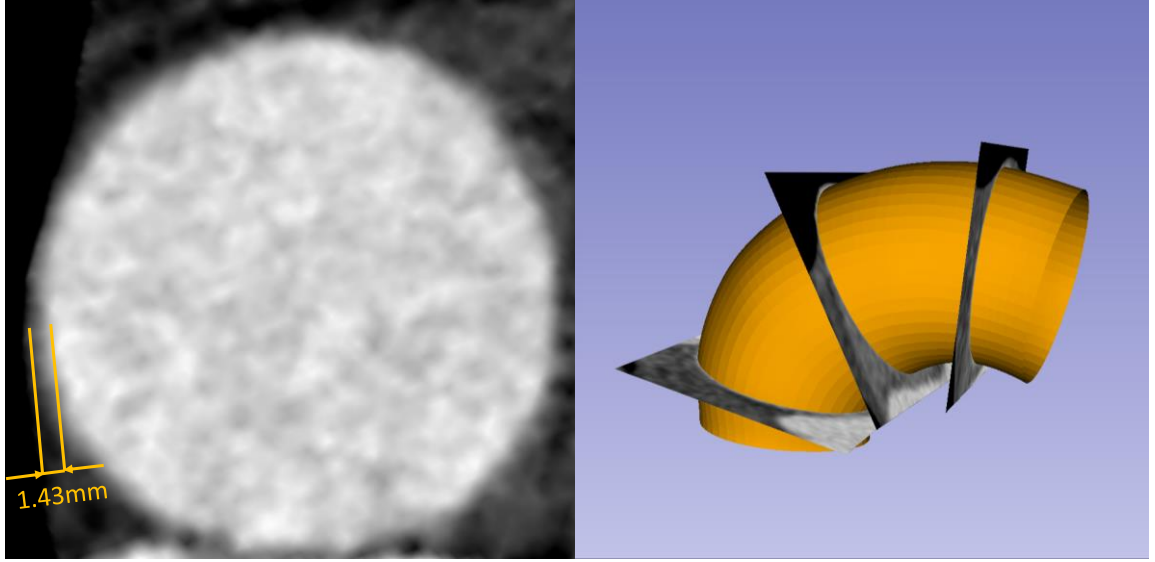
Measuring wall thickness from CT scans.
